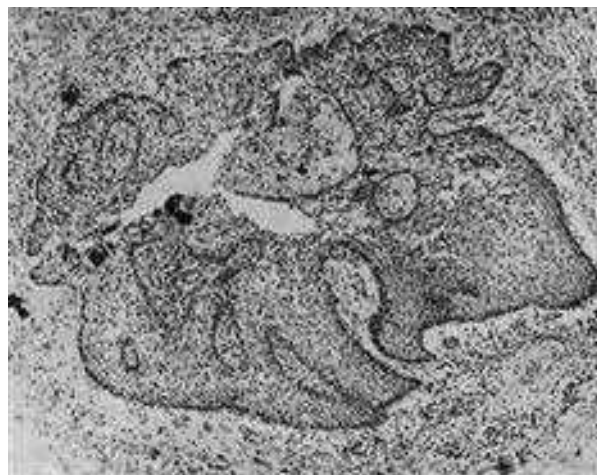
Precystic epithelial proliferation in a periapical granuloma.
